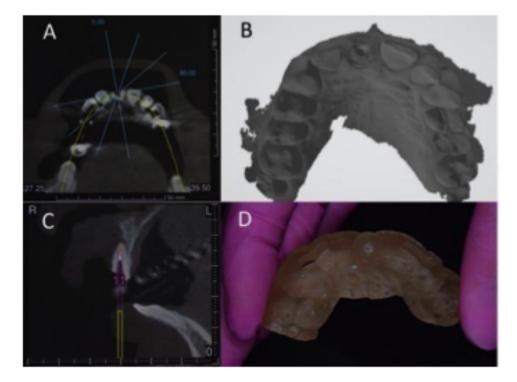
A) and C) Virtual planning of the guided endodontic model in CBCT images in axial section; B) intraoral impression; D) model after impression.
